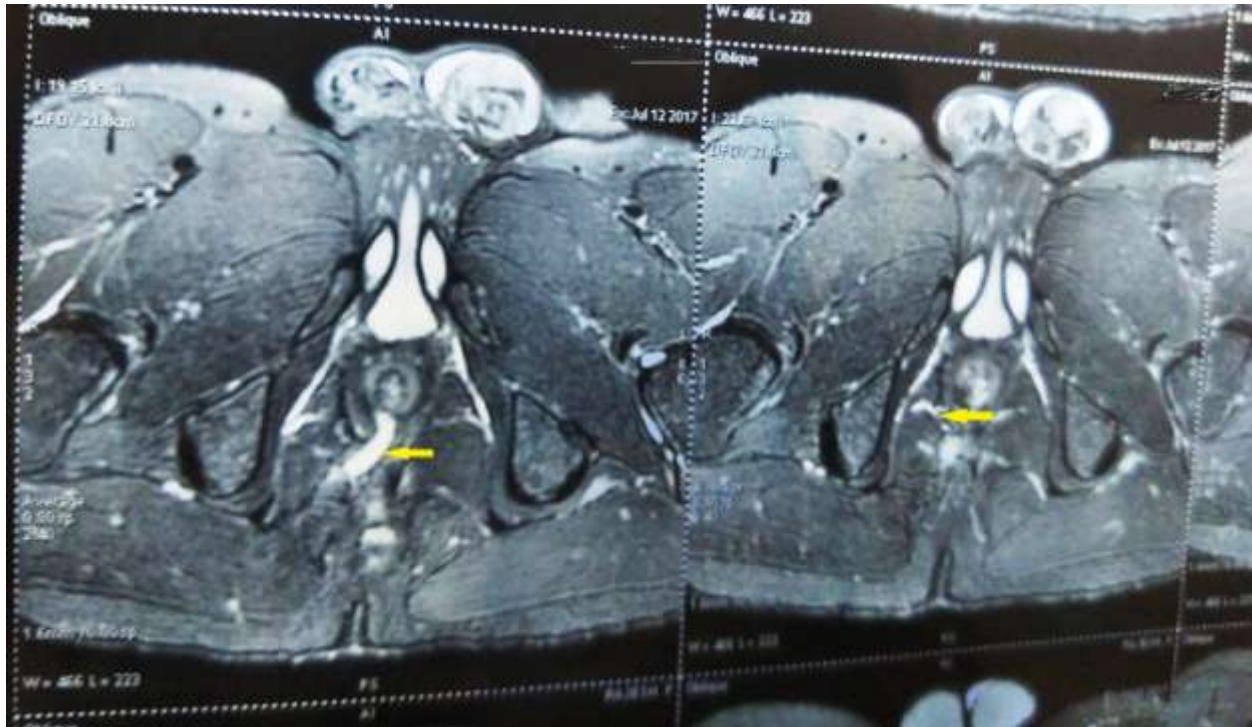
Showing the MRI Fistulogram arrows depicting the fistulous tract and the rami
